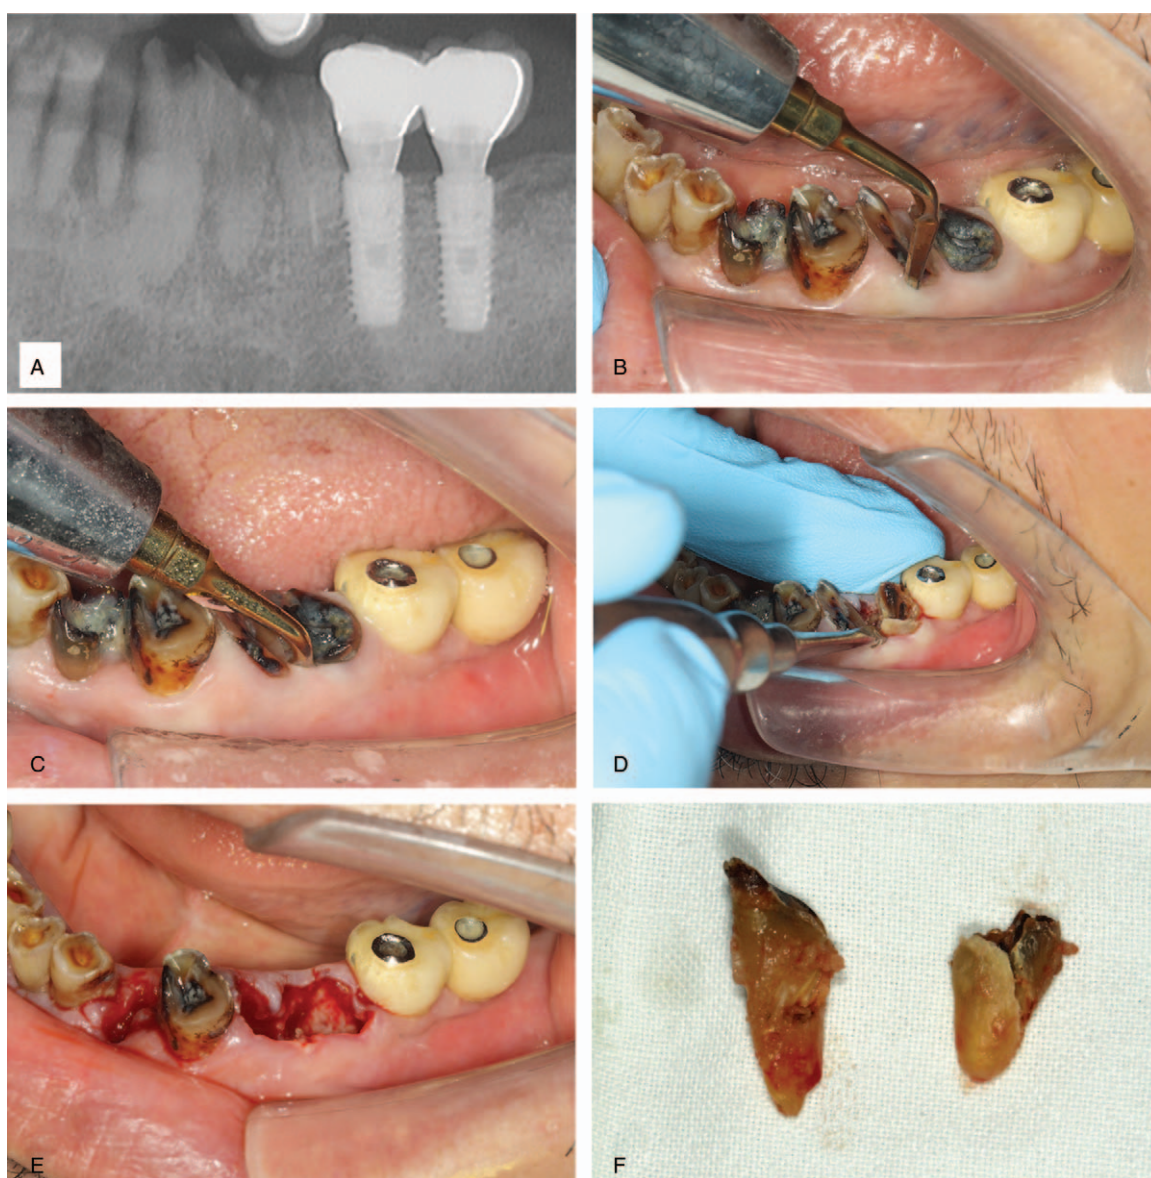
Extraction of residual root that experienced root canal therapy. (A) The panoramic radiograph showed that teeth #34 and #35 were useless residual roots, and tooth #35 underwent root canal therapy. Meanwhile, the periodontal spaces of teeth #34 and #35 were missing, and the boundaries between teeth #34 and #35 and the alveolar bone were hard to identify. Tooth #35 was quite close to tooth implant #36. (B) Piezosurgery was applied to create the extraction space of teeth #34 and #35. (C) The tip was inserted into the alveolar process and stuck to the root. (D) After space was created, teeth #34 and #35 were easily removed by an elevator. (E) No alveolar bone fracture and soft tissue injury occurred during the surgery. (F) The removed teeth were intact.
